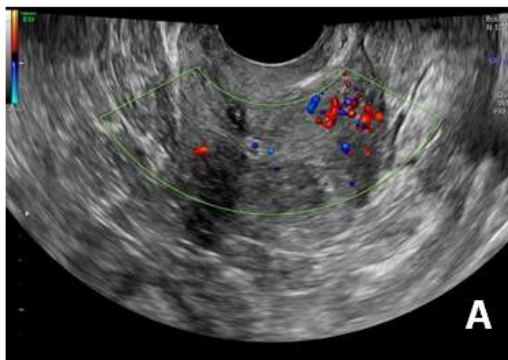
Color Doppler (A) Before (B) After Panchkarma
